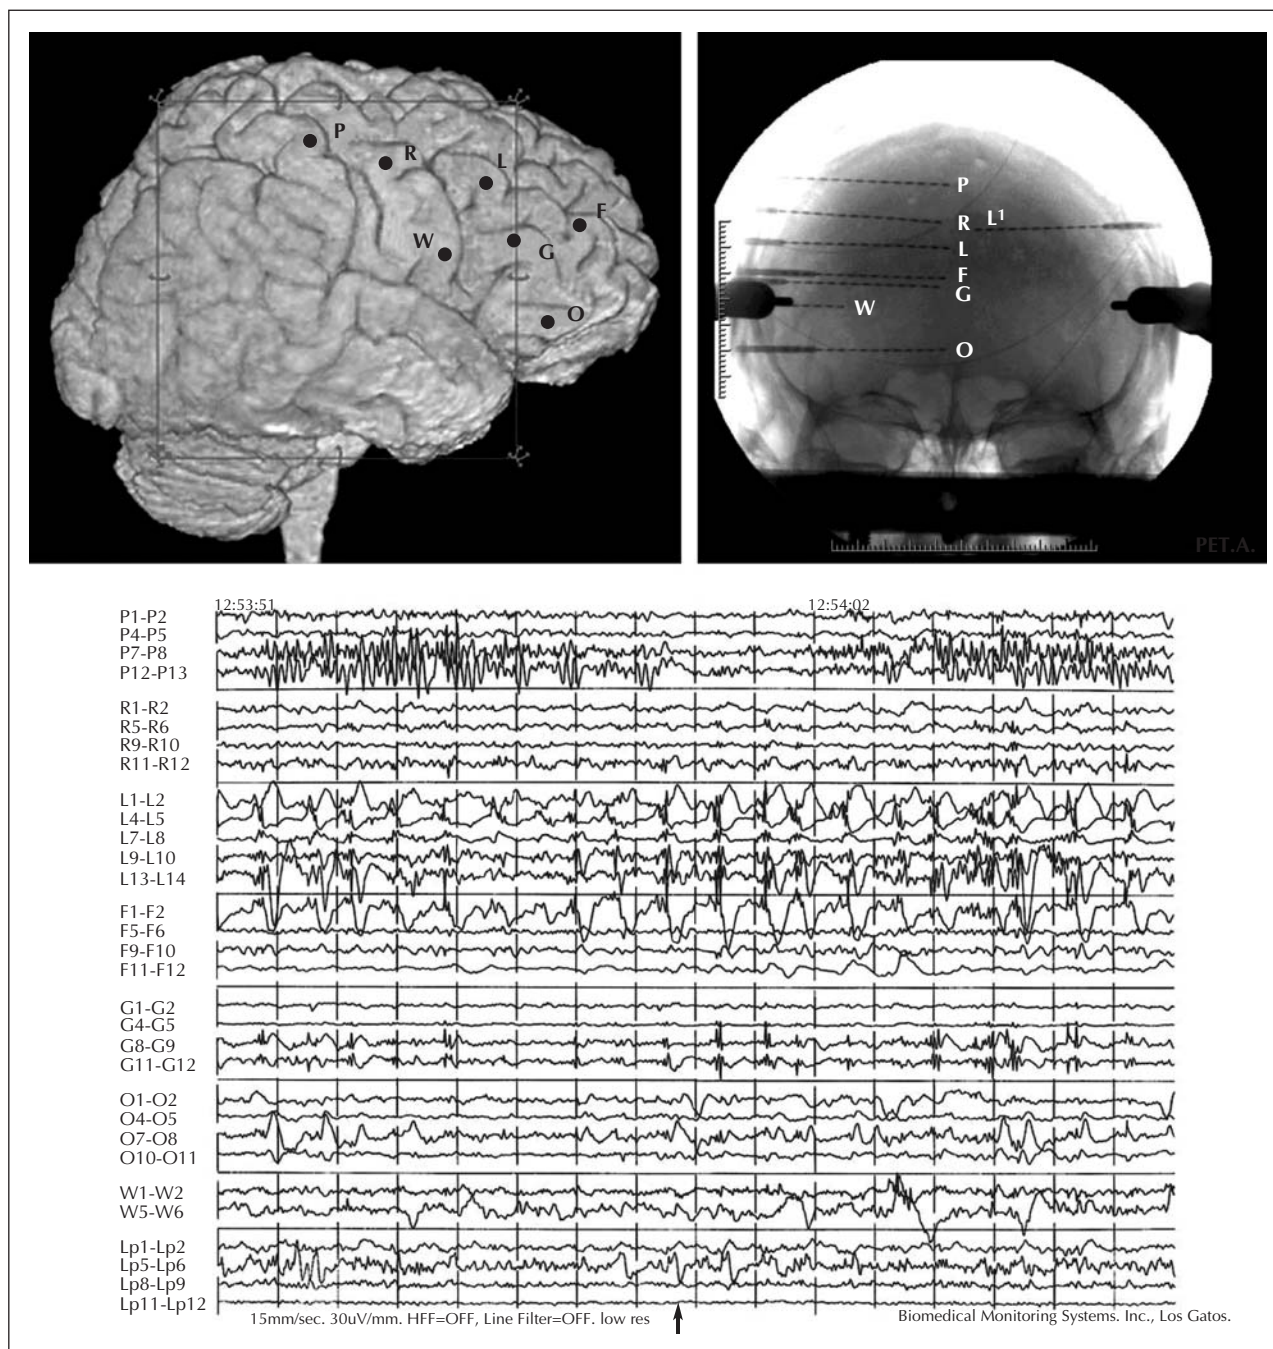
Patient PA. A) Position of the implanted electrodes. Top: on right side of surfacic MRI. Bottom: on X-ray front view of the skull. B) SEEG recording: psychic illusions, visual and auditory hallucinations with polyspikes and waves discharge on L electrode, maximal on L4-L5 contacts exploring superior frontal sulcus. Arrow points when patient indicates.
